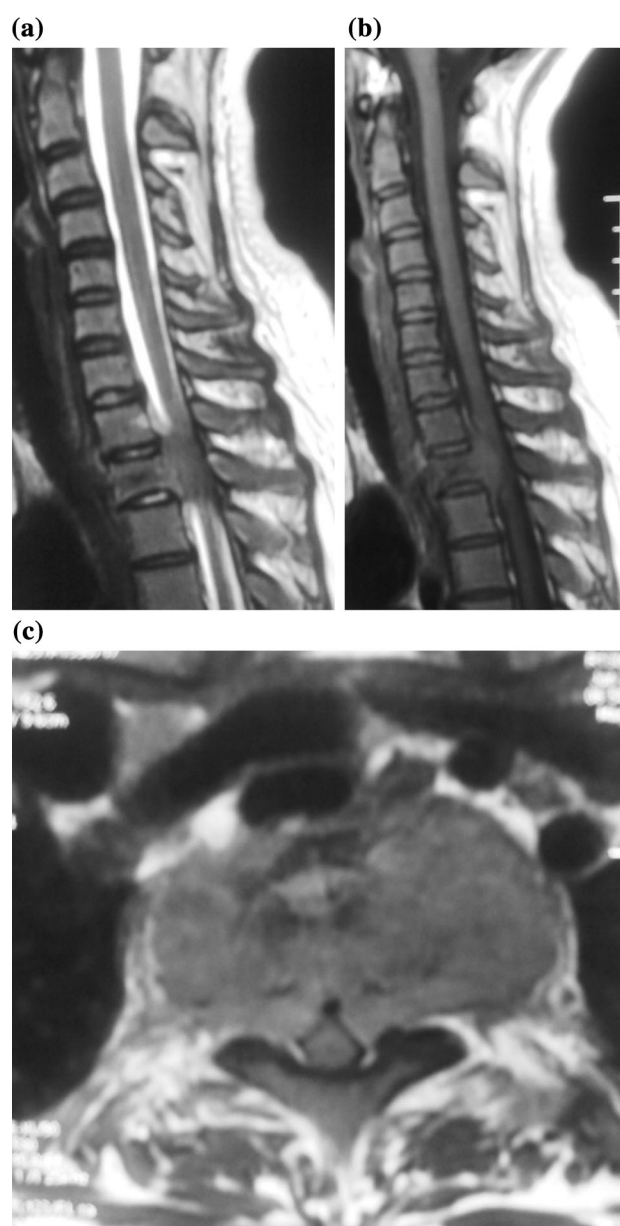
Pre-operative MRI shows pathological lesion of T2 vertebrae. a Sagittal T2-weighted image; b Sagittal T1 image; c axial T2-weighted image
